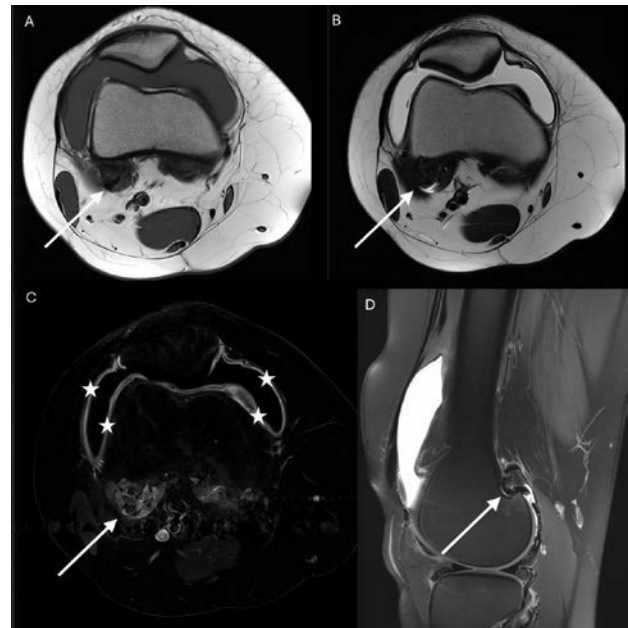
Axial and sagittal MR images of the knee demonstrate a diffuse intra-articular tenosynovial giant cell tumour with a solid nodular component posterior to the medial femoral condyle (arrows). The lesion shows low to heterogeneous signal intensity on T1- and T2-WI as on fat saturated imaging respectively (arrows, A, B and D). The solid nodular component shows heterogeneous contrast enhancement on T1-fs with gadolinium (arrow, C). There is also diffuse synovial thickening and enhancement (stars, C).
